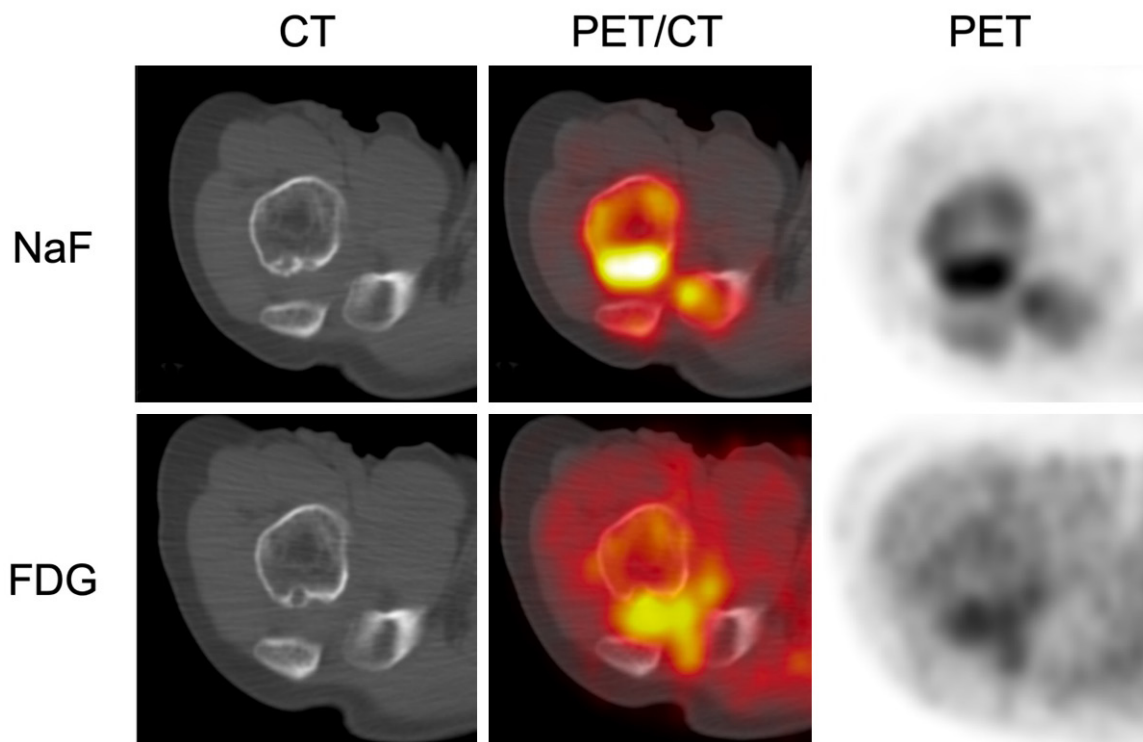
Degenerative changes of the GH joint. CT, fused PET/CT, and PET images of right GH joint of a 61-year-old subject with osteoarthritis and subchondral cyst demonstrating both NaF and FDG avidity.
